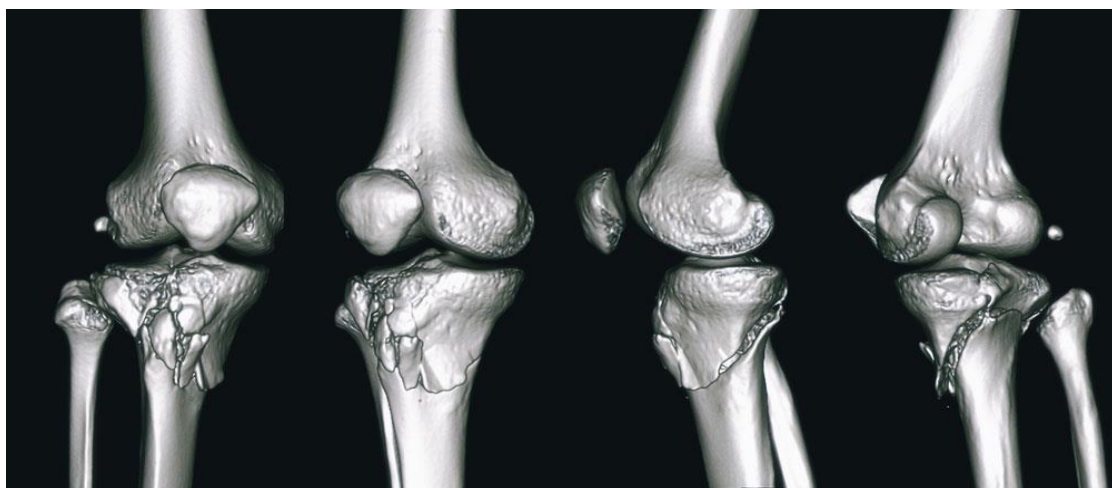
Tibial Plateau Fracture on CT-Scan findings²⁸
